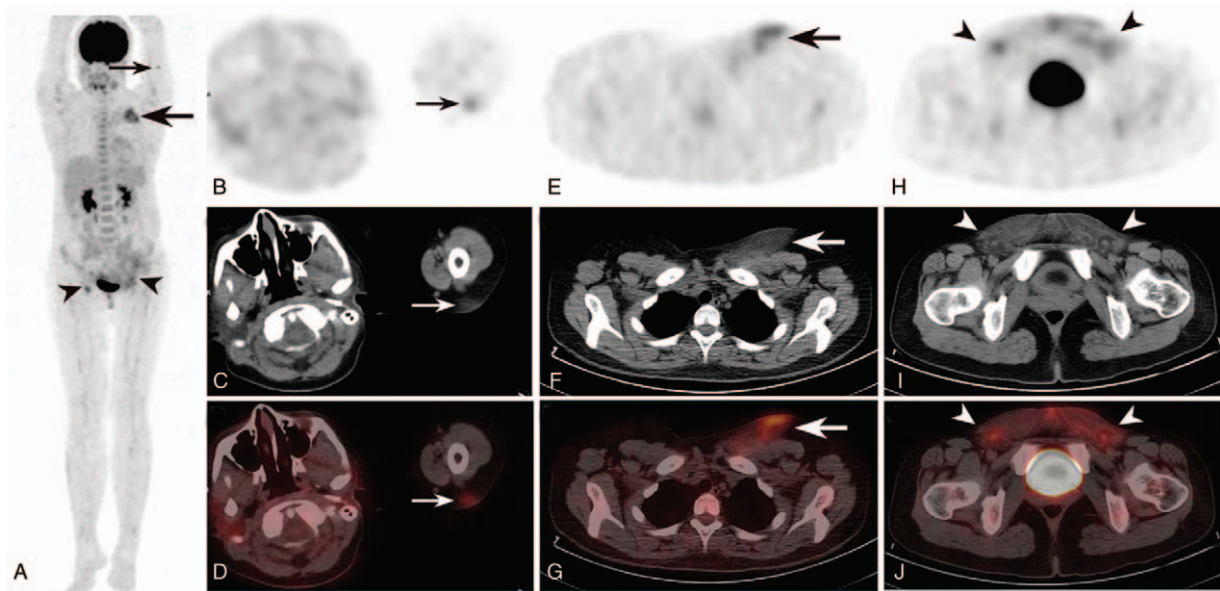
^{18}F -FDG PET/CT images at baseline of relapsed subcutaneous panniculitis-like T cell lymphoma. FDG PET/CT images [(A) Maximal intensity projection (MIP)]; (B, E, H) PET; (C, F, I) CT; (D, G, J) fusion] demonstrated multiple moderate FDG-avid subcutaneous adipose tissue lesions on the left upper arm [(A–D) thin arrows] and perineum [(A, H–J) arrows], involvement of bilateral inguinal lymph nodes, and a markedly increased FDG-avid subcutaneous mass on the left chest [(A, E–G) thick arrows, SUVmax of 5.01], suggestive of relapsed SPTCL. ^{18}F -FDG = ^{18}F -fluoro-2-deoxy-D-glucose, MIP = maximal intensity projection, PET/CT = positron emission tomography/computed tomography, SPTCL = subcutaneous panniculitis-like T cell lymphoma, SUVmax = maximal standardized uptake value.
